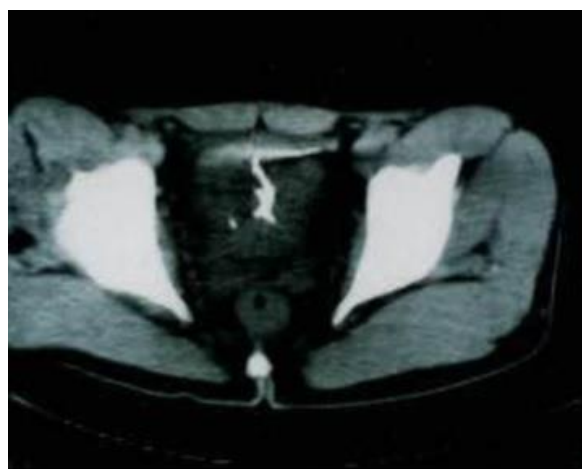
Pelvic computed tomography scan; a curved fine high-density mass in the bladder
